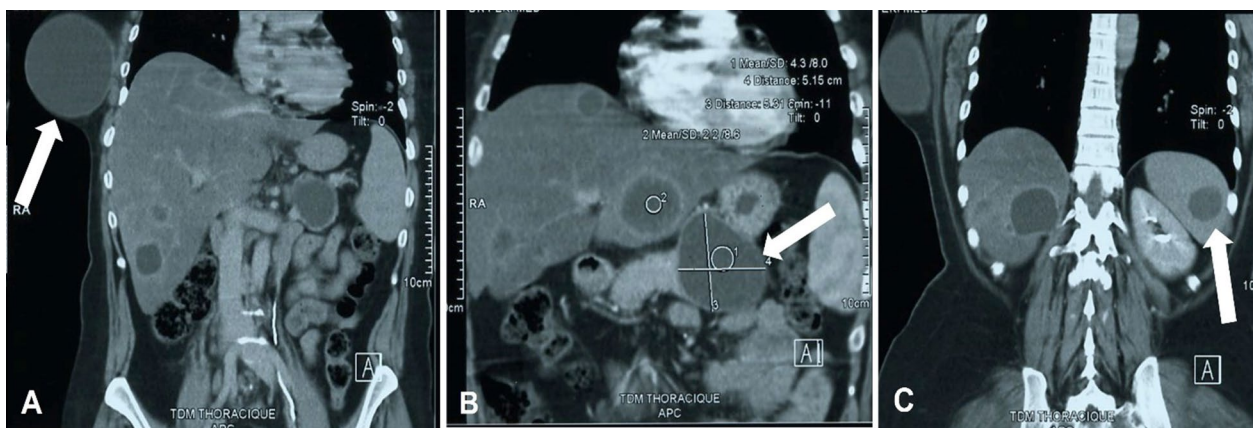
Abdominal computed tomography scan showing right axillary hydatid cyst (arrow) (A), pancreatic hydatid cyst (arrow) (B) and splenic hydatid cyst (arrow) (C)
